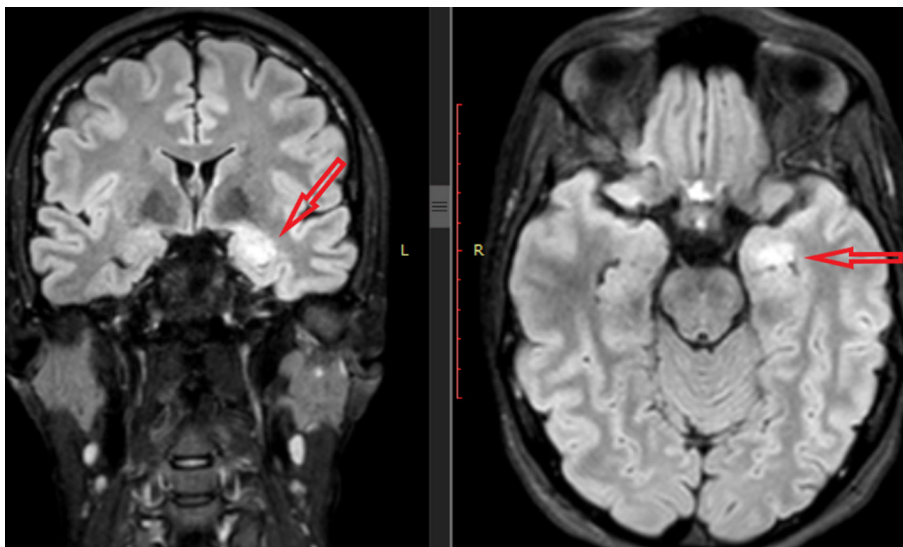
MRI (3 T) of the brain according to "epilepsy" protocol (sections on the anatomical axis of hippocampus). Mesial temporal sclerosis on the left (own observation)
